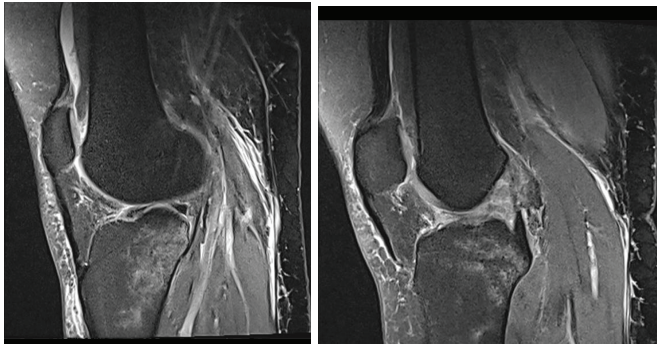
(ACL Tear): PD sagittal MR image in a 28-year-old male sprint runner shows rupture of ACL with marrow edema in proximal tibial, joint effusion and subcutaneous edema.
